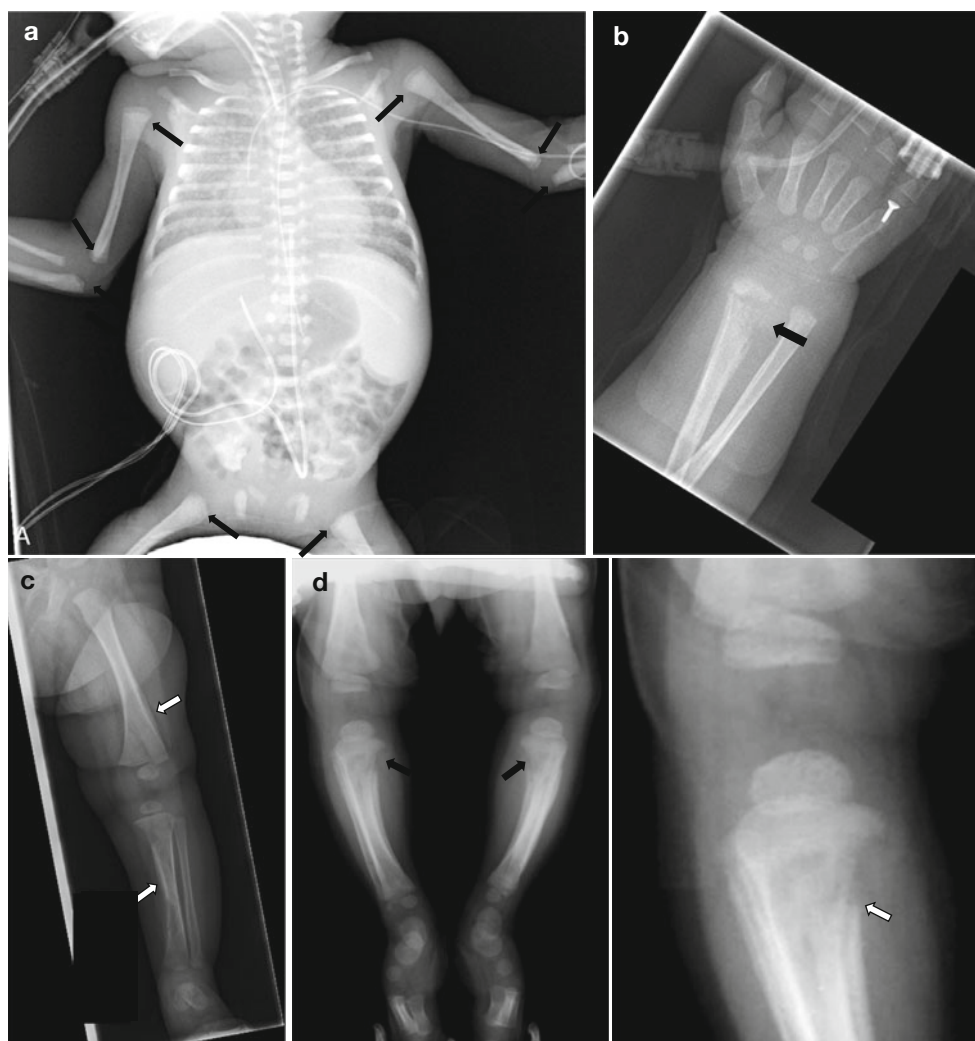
Congenital syphilis.* (a) Infantogram of a newborn baby demonstrates multifocal metaphyseal lucent bands (arrows). (b, c) A 2-month-old boy with congenital syphilis. Radiographs of the wrist (b) and lower leg (c) demonstrate metaphyseal lucencies (black arrow) and multiple areas of periosteal new bone formation (white arrows).
